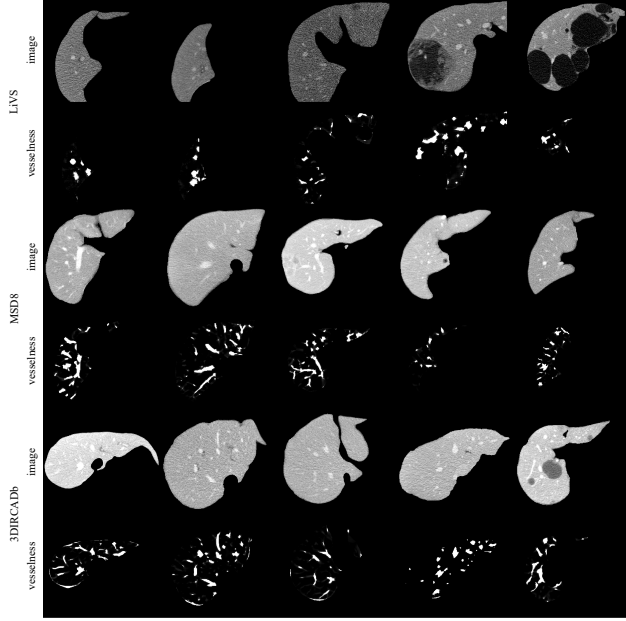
Visualization of images and their corresponding vesselness filtering results. In the CT images, regions with high intensities represent hepatic vessels, while dark regions indicate tumors. In the paired vesselness filtering results, high-intensity patches correspond to vessel candidates, with noise visibly present along the liver border.
